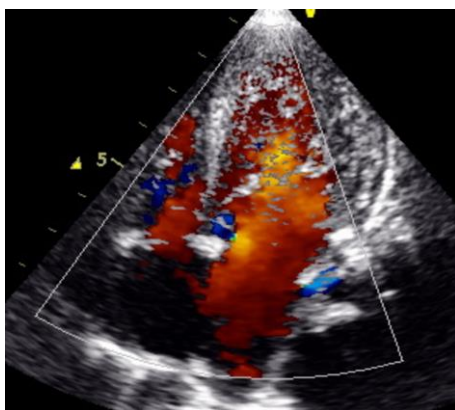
Two-Dimensional Echocardiogram In Apical Four Chamber View Showing Colour Doppler With Flow Within The Inter-Trabecular Recesses Consistent With LV Non-Compaction.
